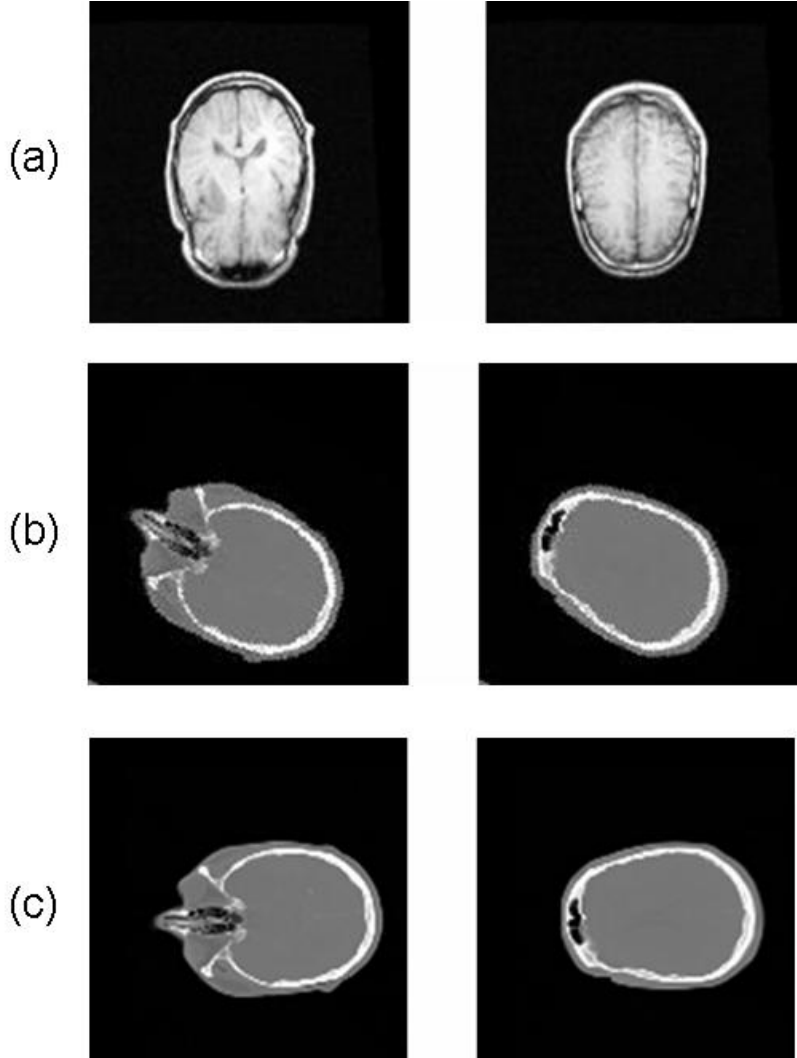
(a) MR volume (fixed image data); (b) CT volume (moving image data) of experiment 1 ((b) to (a)); (c) CT volume (moving image data) of experiment 2 ((c) to (a))
